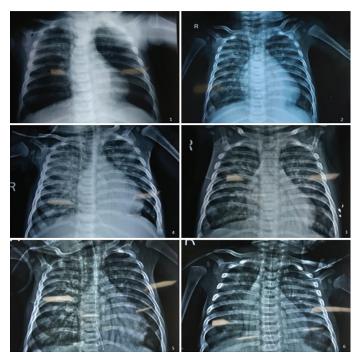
Chest X-rays 1and 2 were taken during the 1st session of treatment. Here, X-ray-1 shows that there is mild lower respiratory tract infection and X-ray-2 shows bilateral patchy infiltration. X-ray-3 was taken in the 2nd session in which perihilar infiltration was observed. Hyperinflated lungs and interstitial pneumonitis were seen in X-ray-4 considered during the 3rd session. In the 4th session through X-rays 5 and 6, spur-like appearance of scapula, widening of costochondral junctions, heart contours obliterated by bilateral interstitial opacities, and absence of thymic silhouette were observed
